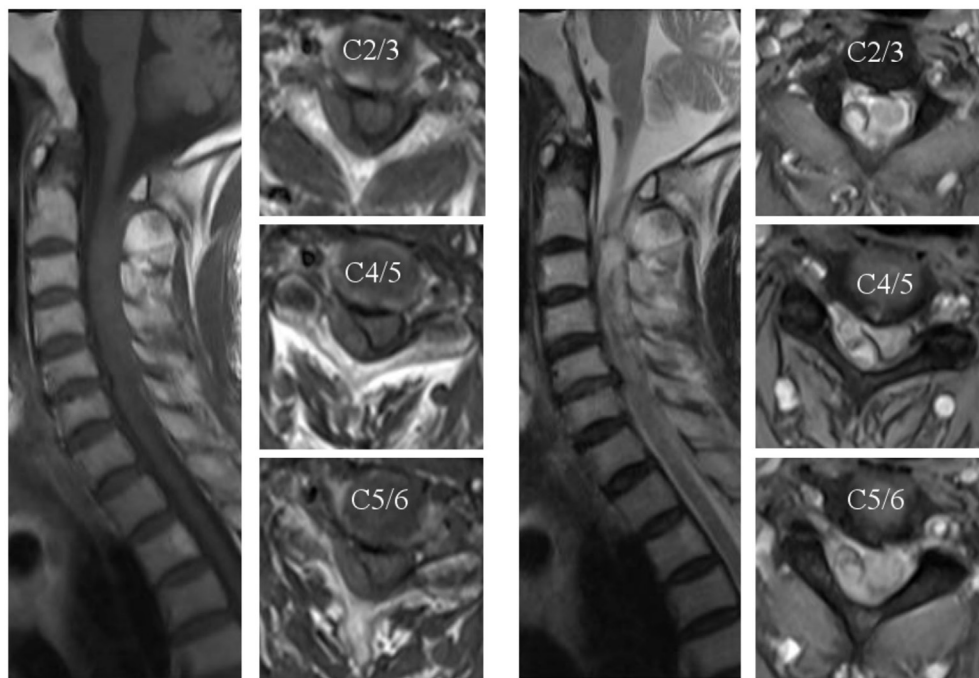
MRI T1-weighted images (Left) and T2-weighted images (Right) indicated acute epidural hematoma with isointensity on T1-weighted image, and iso-/relatively high intensity on T2-weighted image.
